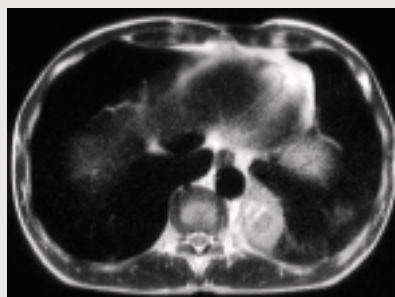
T2-weighted image
